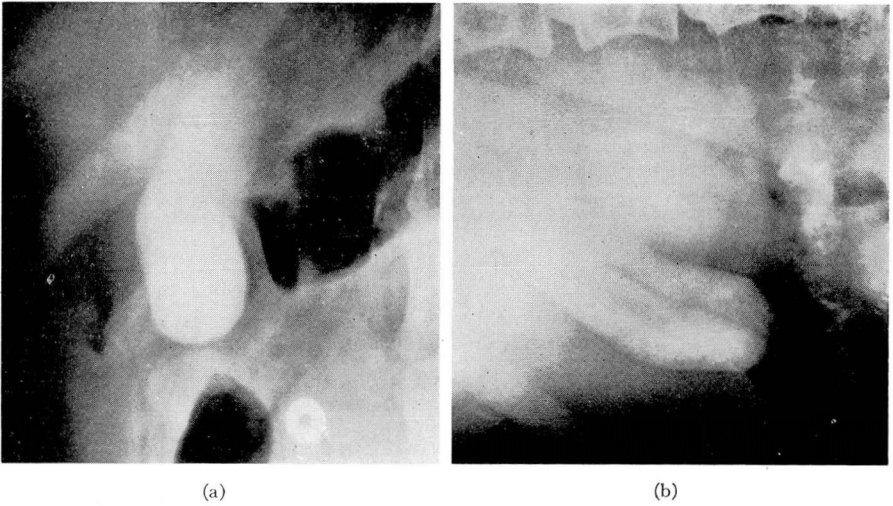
Cholelithiasis. (a) Posteroanterior prone roentgenogram showing what appears to be a normal gallbladder free of calculi. (b) Posteroanterior lateral decubitus roentgenogram revealing that a few nonopaque calculi have settled to the bottom.
